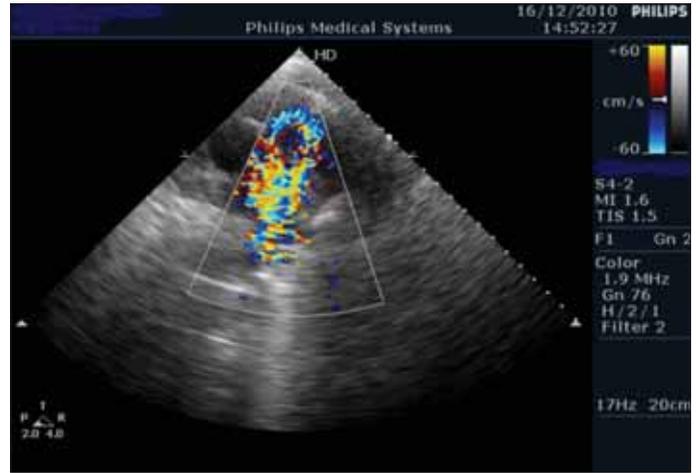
Transesophageal echocardiography color Doppler image of a pulmonary artery cyst
